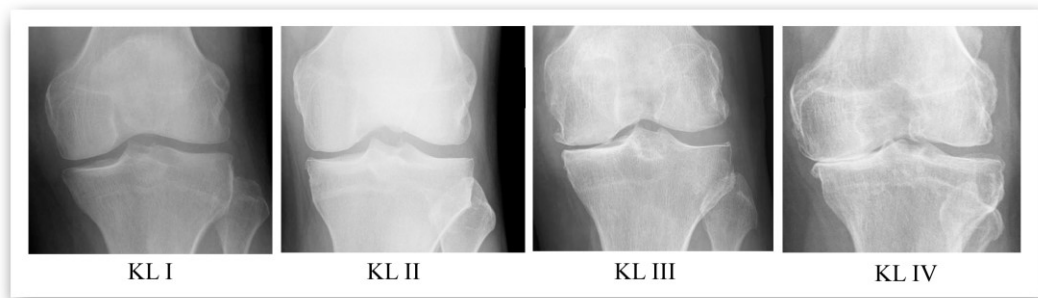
Randomly selected knees with OA radiograph scores from 1-4 on the Kellgren and Lawrence scale⁵⁴.
